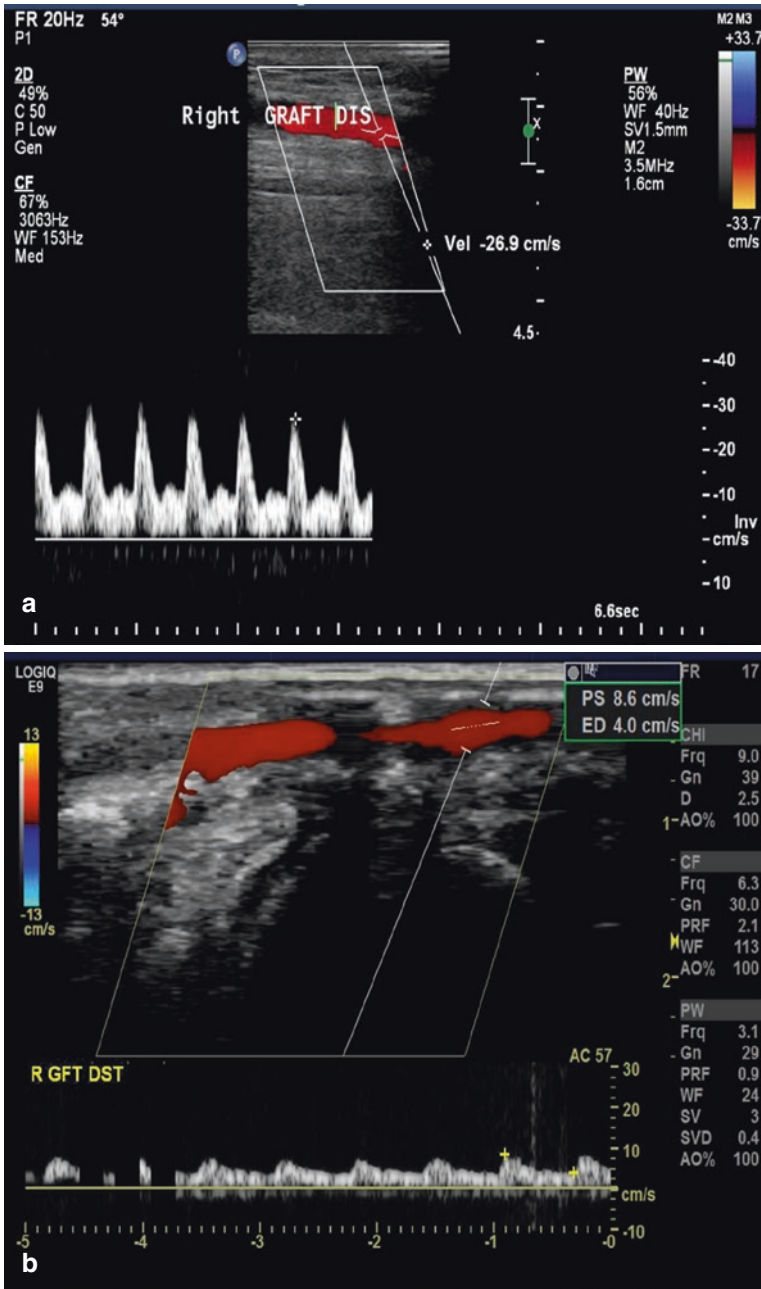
Example of a patient with a below knee popliteal to below ankle level bypass graft with reducing velocity on serial scans and significant stenosis requiring angioplasty but mean graft velocity was always above the usual threshold requiring intervention. (a) Surveillance >2 years with flow below 0.45 m/s the usual threshold given for an at-risk graft but foot lesions were healed and no severe stenosis was found on ultrasound so routine surveillance. (b) Then subsequent surveillance shows drop in velocity and associated change in waveform due to progressive inflow stenosis (c) Angiogram showing inflow stenosis of popliteal artery (arrow)
